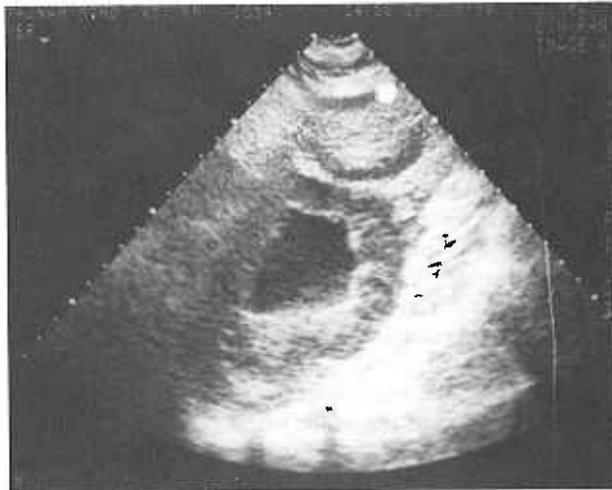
Ultrasound of the liver showing an echogenic and a cavitating mass in the right lobe of the liver
